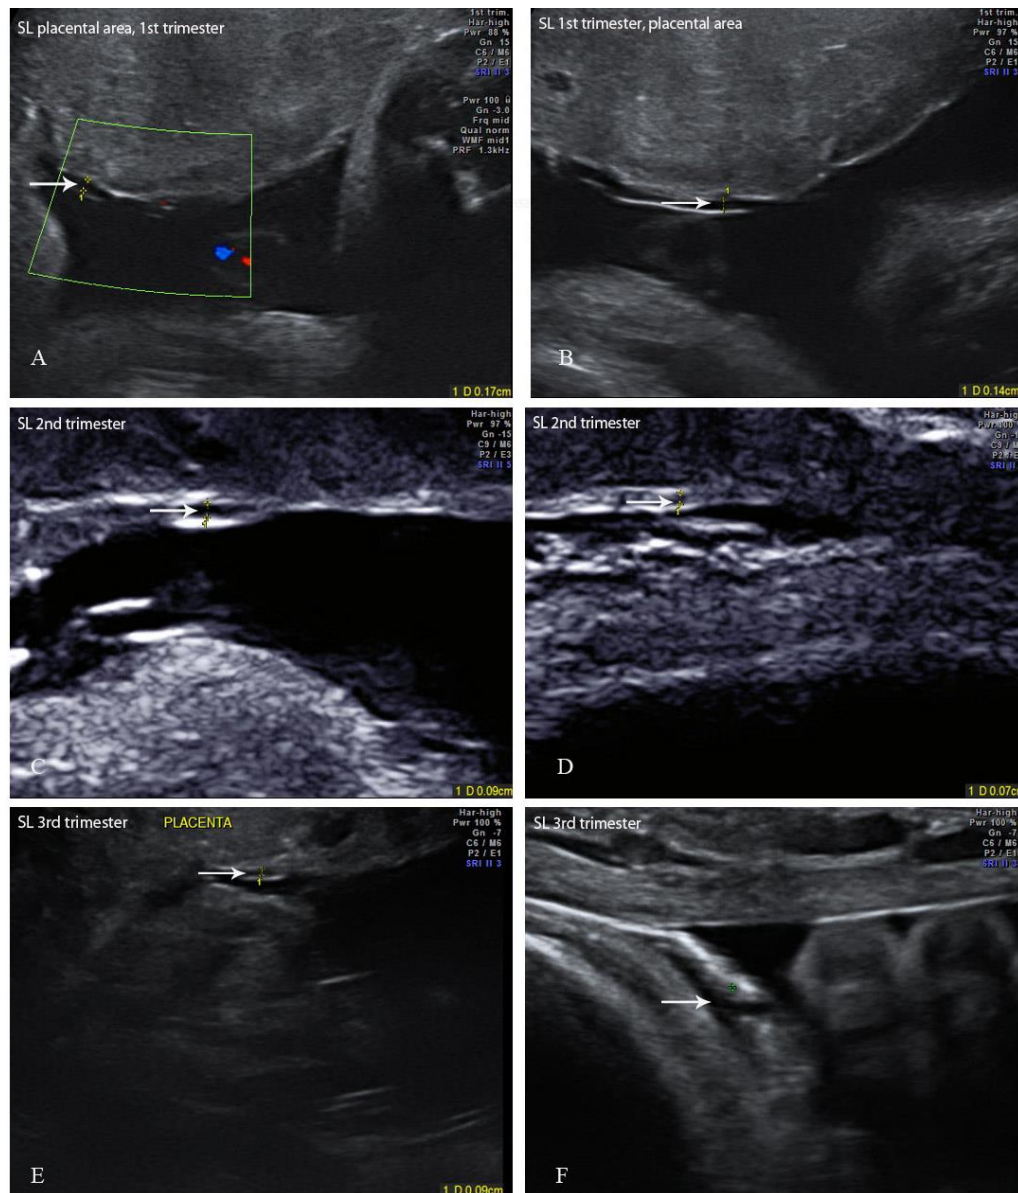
SL ultrasound measurement.
